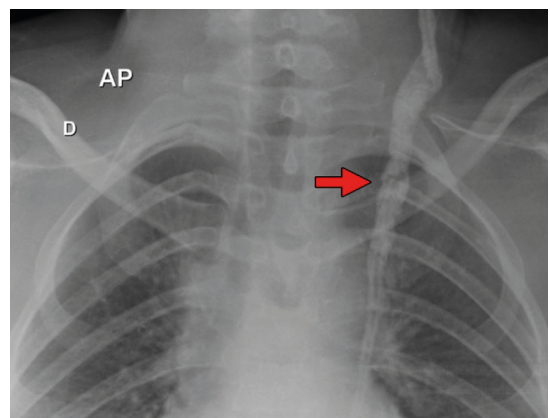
Anteroposterior chest X-ray showing a ventriculoperitoneal shunt catheter with a path in the left hemithorax, calcified, with a fracture point (red arrow) at the level of the second/third rib arches.
